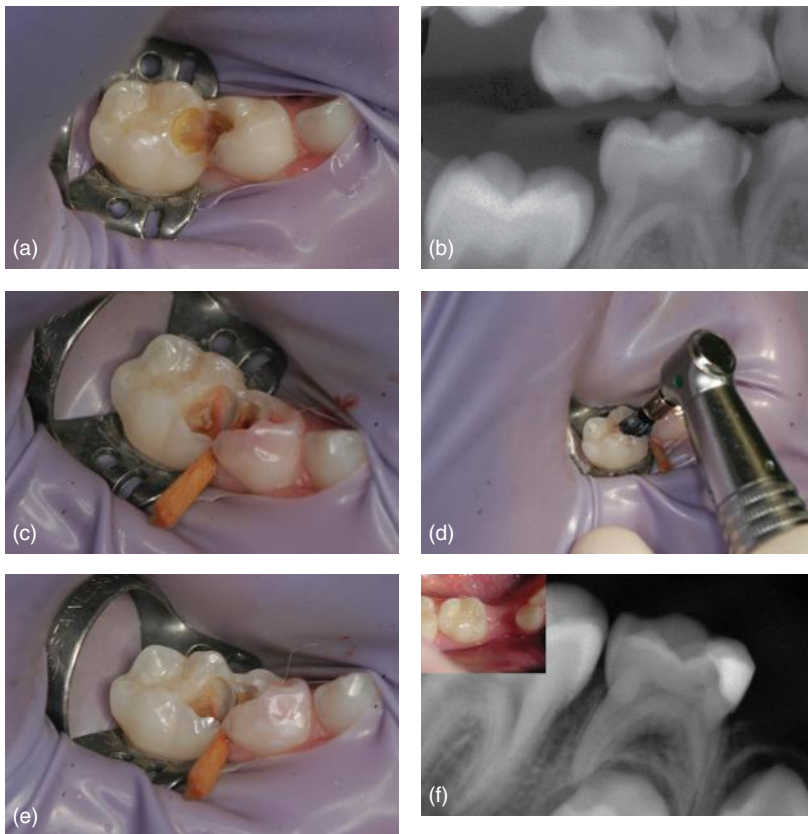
(a) Second deciduous molar with deep carious lesion before indirect pulp treatment. (b) The same tooth on bitewing. (c) After excavation of the dentine-enamel junction. (d) Removing very soft, infected dentine with a rotating prophylaxis brush and fluoride tooth paste only. (e) The completed, dried cavity. A resin-modified glass ionomer liner (Vitrebond/3M Espe) was applied and the cavity was restored with a compomer (Dyract/Dentsply Caulk). (f) Clinical and radiographic result after 2 years and 4 months.
